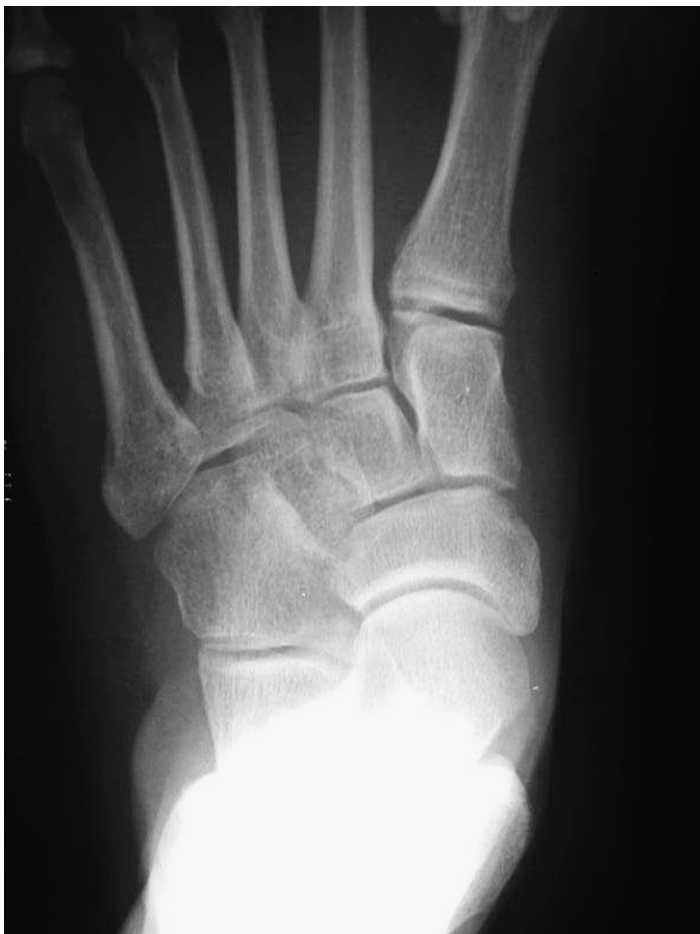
Preoperative anteroposterior radiograph of a 68-year-old female who presented with a painful collapsed pes valgus deformity. Note the subluxation of the talar head from the navicular and the increase in Kite's angle.
